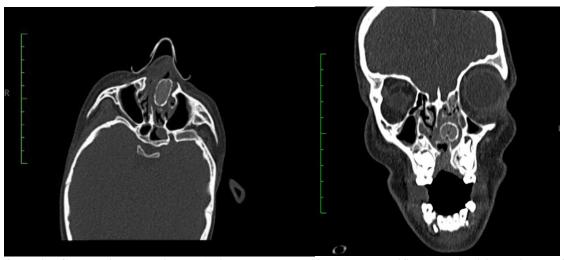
Facial CT scan in bone window (axial and coronal slices): The calcified mass is visible without signs of bone erosion or involvement of adjacent bony structures, which supports the diagnosis of rhinolithiasis
